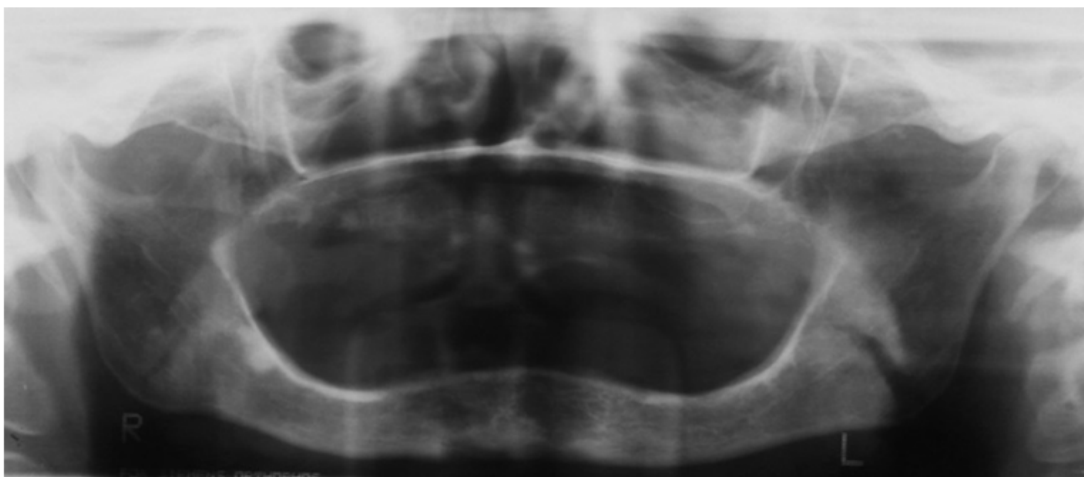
Initial panoramic radiograph
